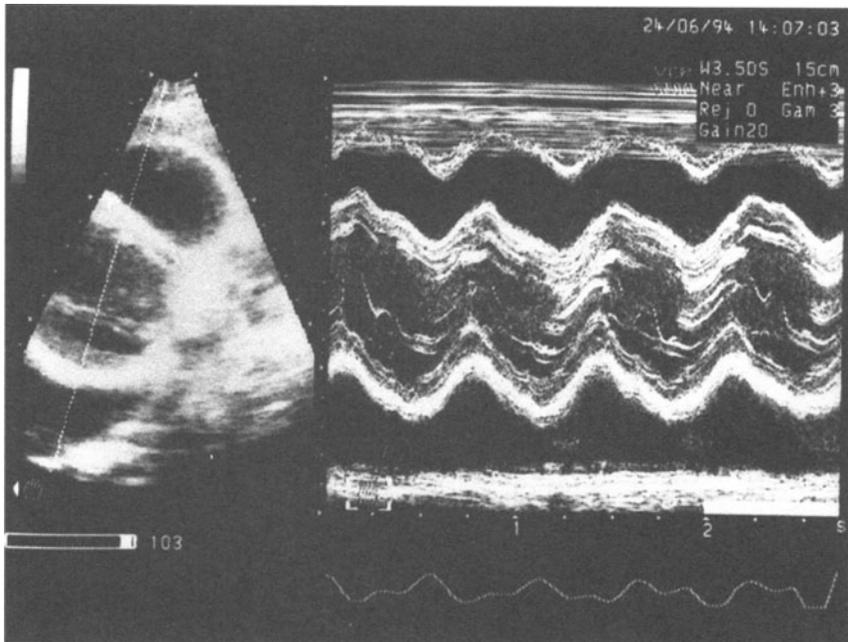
Echocardiogram of 24-year-old Asian man with large pericardial effusion showing substantial pericardial fluid and debris. Fluid lymphocyte-rich exudate with positive culture for *M. tuberculosis*. Rapid response to corticosteroids and drug therapy.
